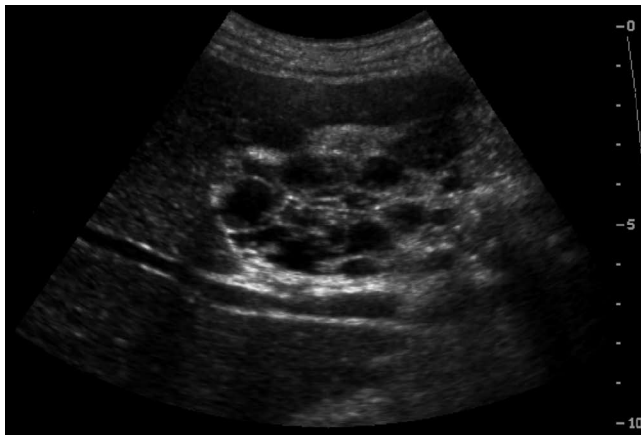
Abdominal ultrasonography showing multi-loculated cystic mass and intact gallbladder lumen.
